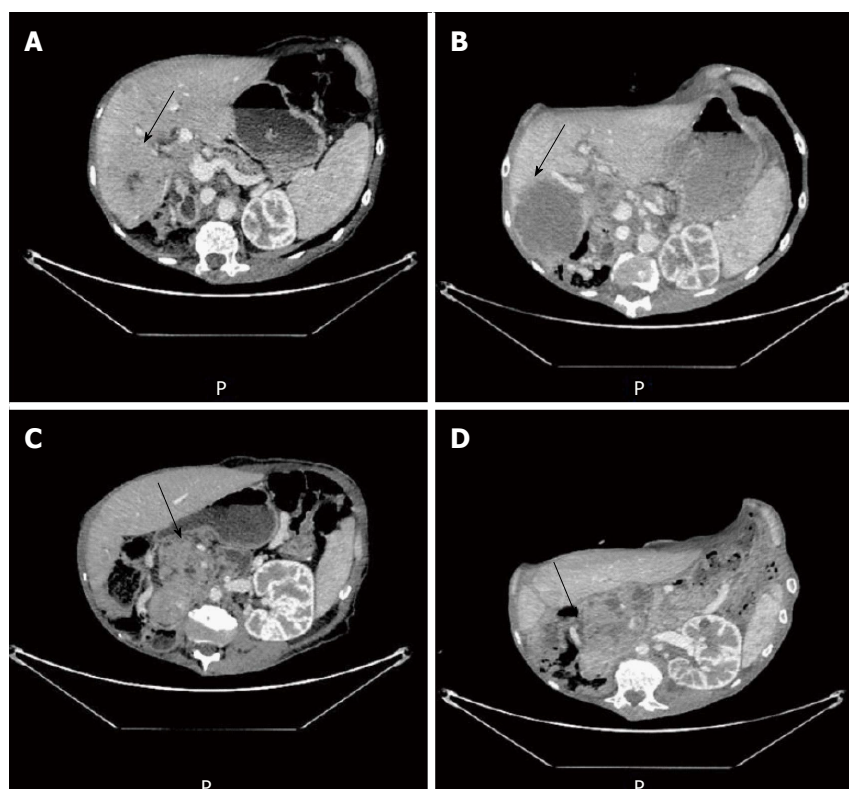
Primary tumor and liver metastasis response to FOLFIRI plus panitumumab. A and B: CT scan axial images of liver metastasis at baseline and 4 wk of therapy; C and D: Axial images of at primary pancreatic tumor at baseline and 4 wk of therapy. Lesions are indicated by a arrow.
